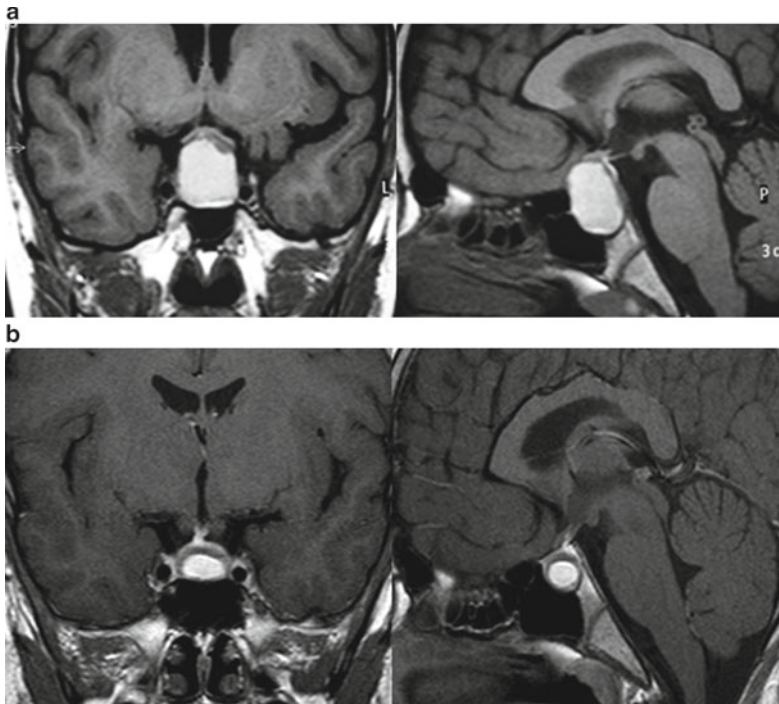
(a) Before treatment. Sellar T1-weighted MRI after gadolinium enhancement, coronal (*left*) and sagittal (*right*) depicted a sellar mass impinging optic chiasma. (b) After 1 year of treatment with CAB. Sellar
